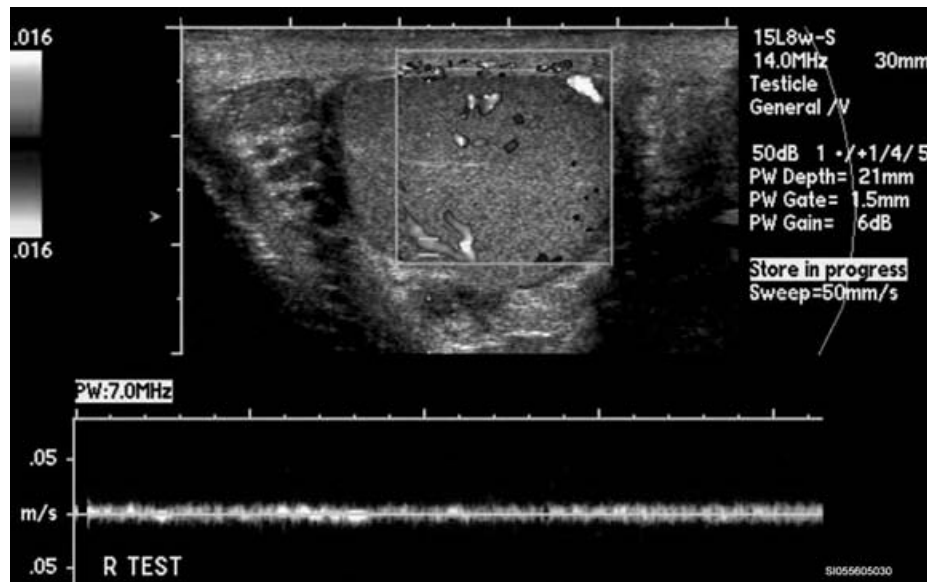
Venous flow in the testis on spectral Doppler.
